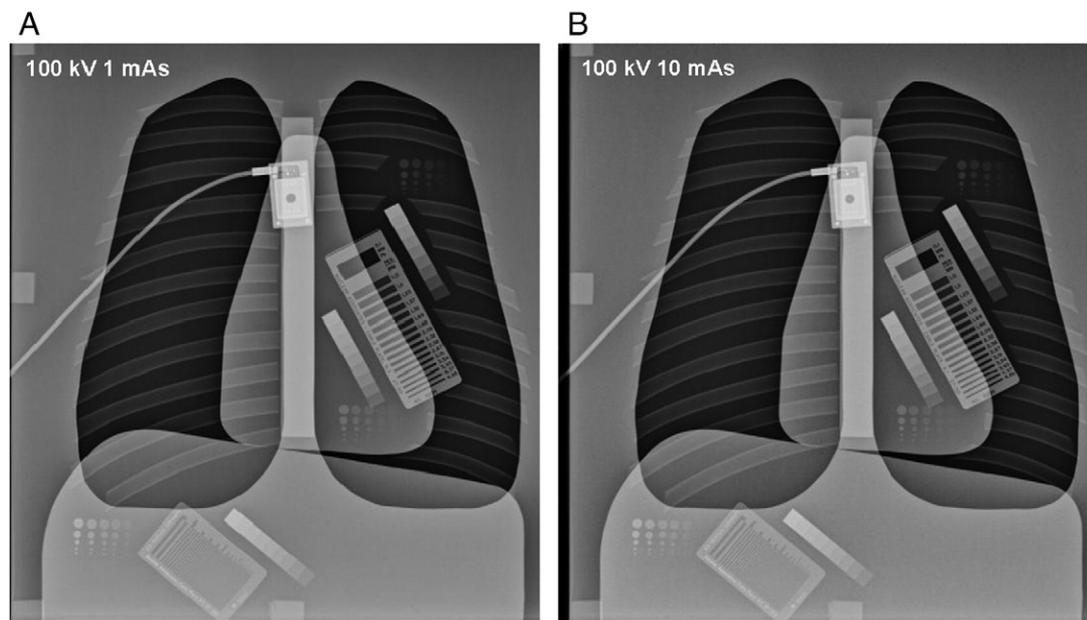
Chest radiographic images were acquired using Toshiba DR system with 100 kVp and 1.0 and 10.0 mA (A, B). There is no significant difference among these images in terms of image quality, but dose reduction was significantly different when the lower mAs were used compared to higher mAs.
